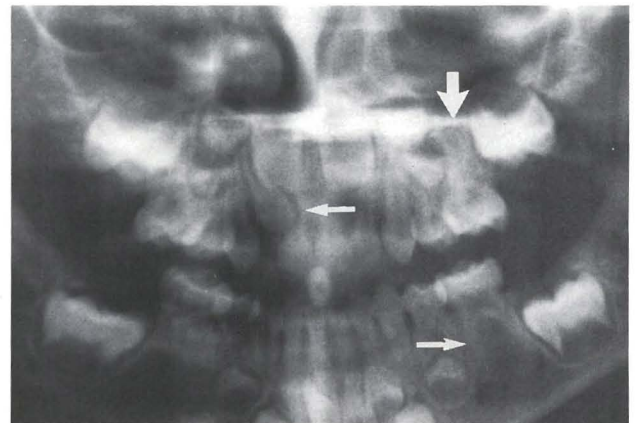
Panoramic radiograph shows several anomalies (arrows).
